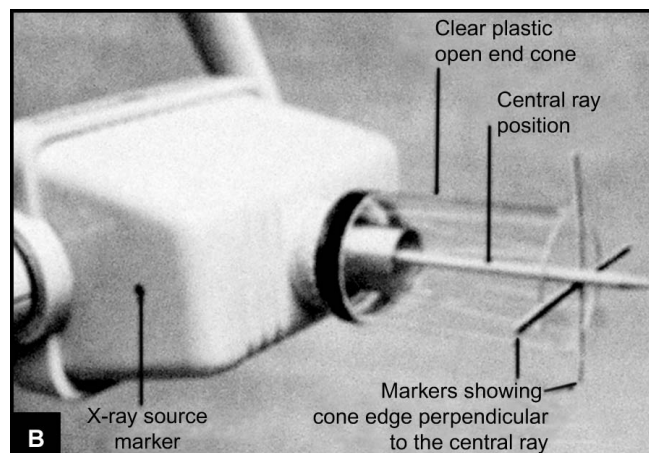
X-ray tube head showing X-ray source location and beam locating open end cone. Note the line on any surface end of cone is always perpendicular to central ray
